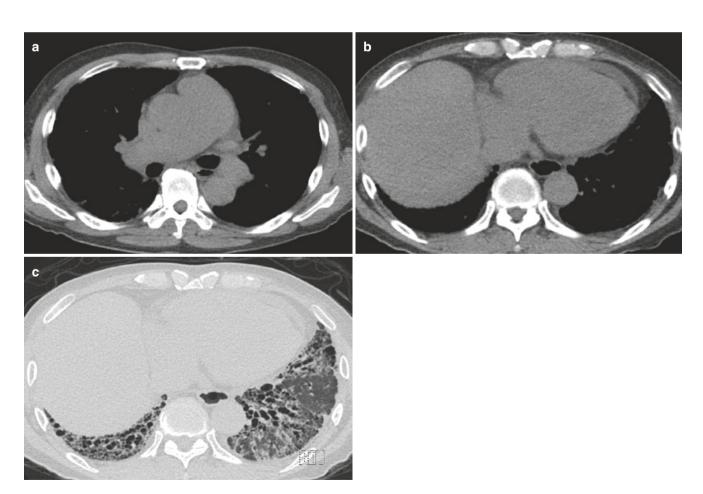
Scleroderma-related ILD. (a-c) Axial CT images show small pericardial effusion, dilated pulmonary artery, air-fluid level in midesophagus, patulous lower esophagus, and fibrotic lung disease
